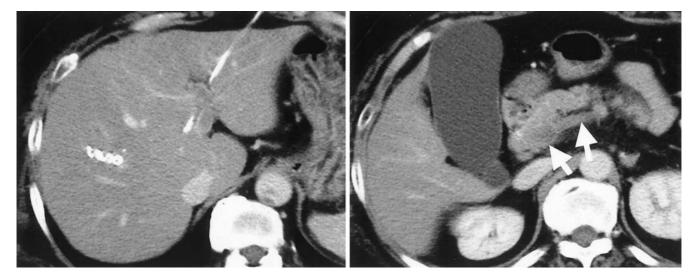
Computed tomography 14 days after portal vein embolization. Arrows indicate massive portal and mesenteric vein thrombosis. Left, umbilical portion of the left portal vein; right, superior mesenteric vein below the pancreas
